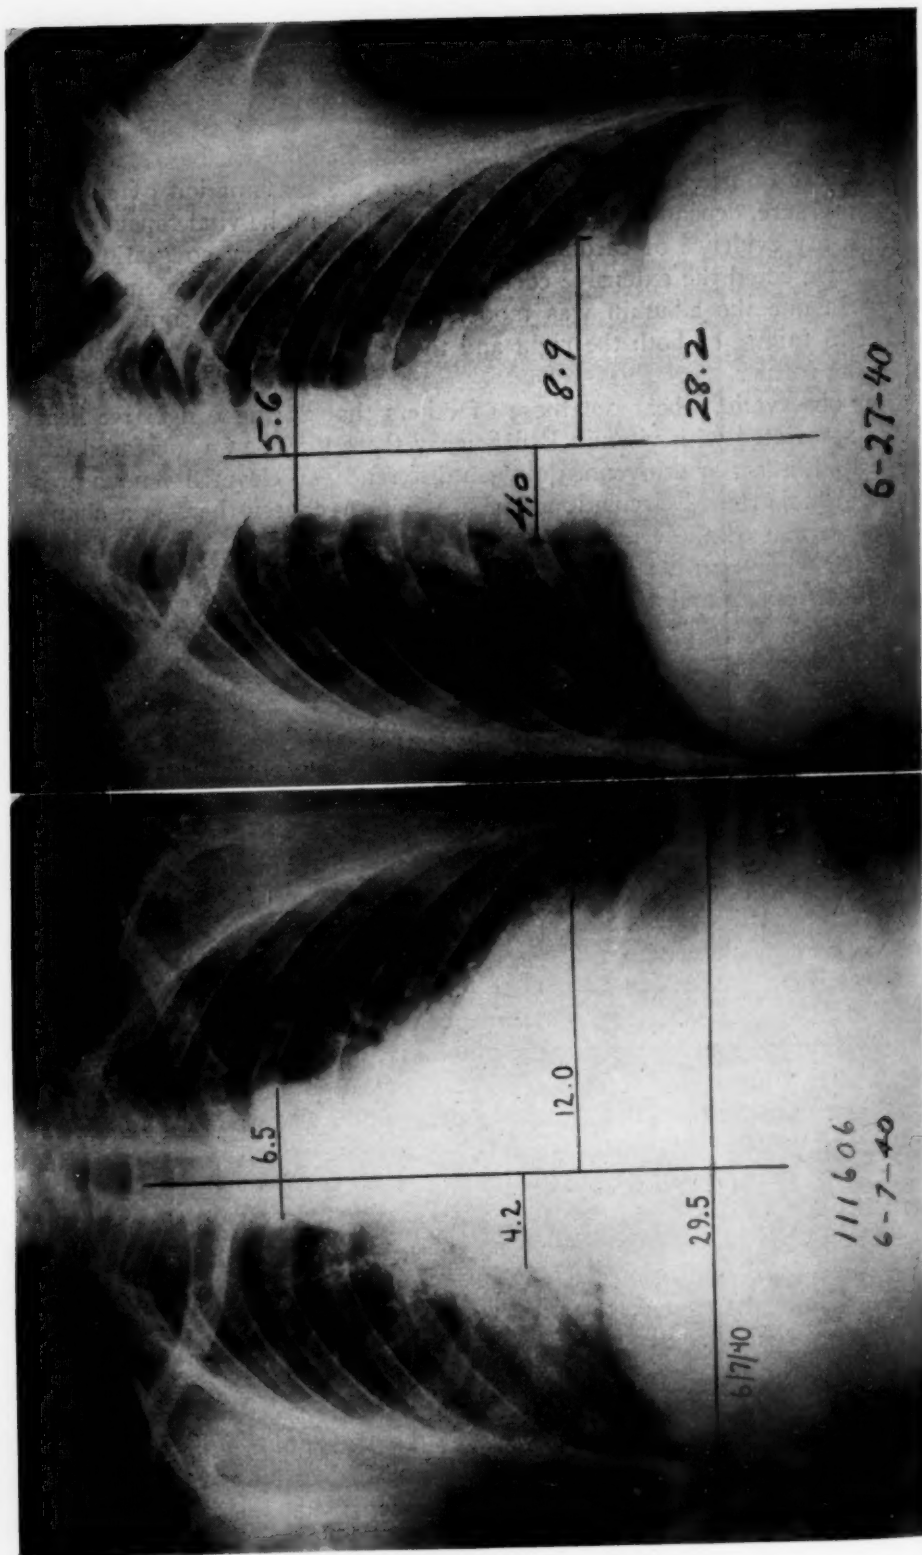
Roentgenograms of patient 1 on admission and 20 days after treatment was begun.
